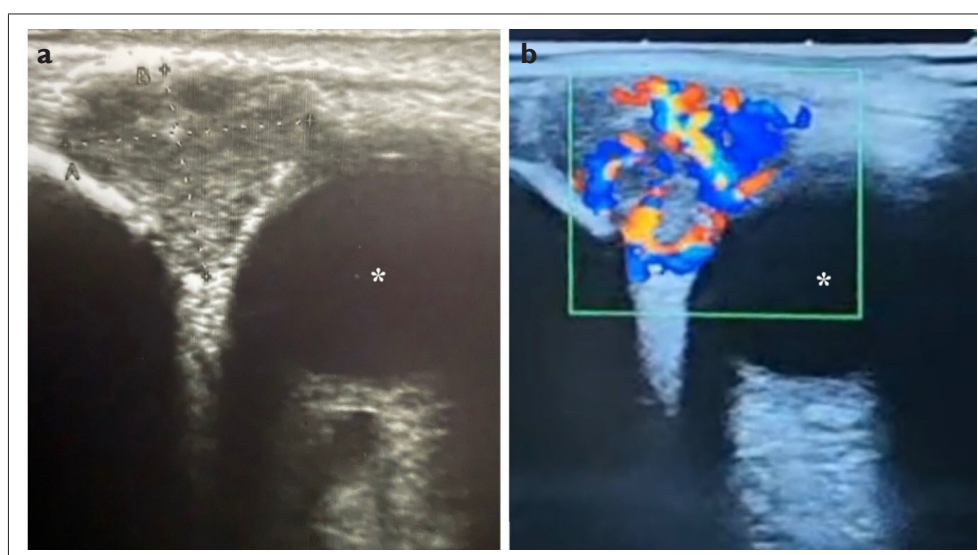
Ultrasonography revealed hypoechoic solid lesion, 3 × 1 cm in size, with indistinct borders (a). Doppler ultrasonography showed an increased vascularity and high-flow pattern (b). *Left eye
